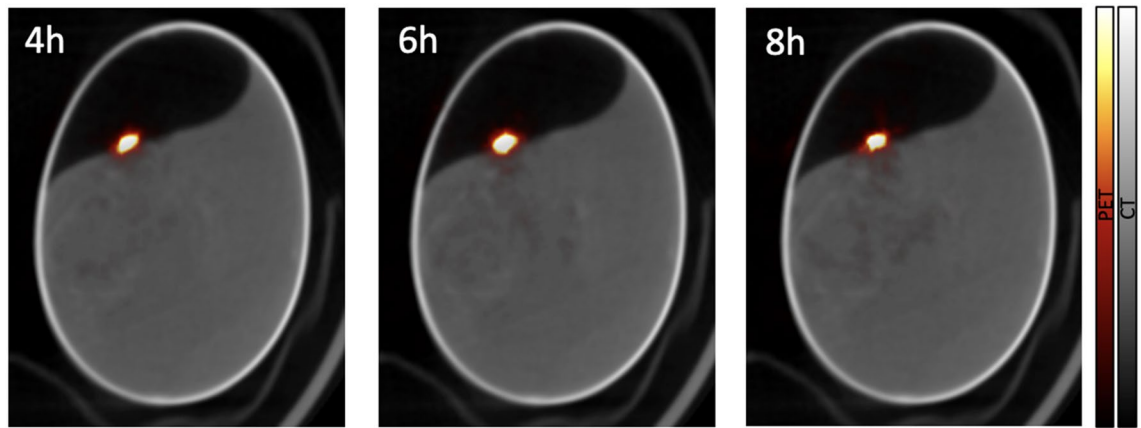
Fused PET and CT images obtained for E1 acquired 4 (left), 6 (middle), and 8 (right) hours after irradiation. The color scale of the PET images was adjusted for each particular image.
